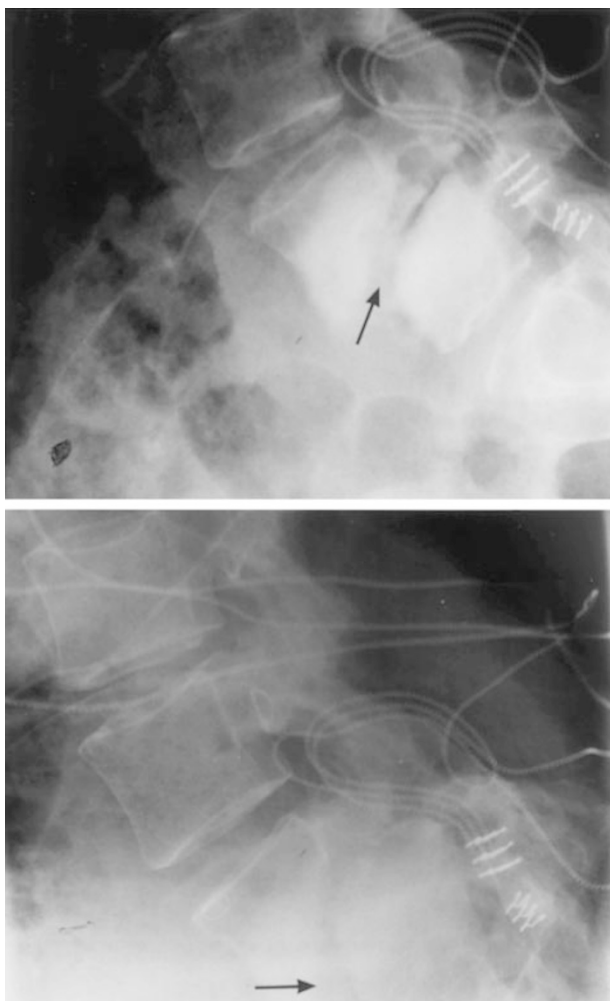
Top—Lumbar spine X-ray when patient was in supine position. Bottom—X-ray when the patient was sat up, showing significant forward movement of L4 on L5
